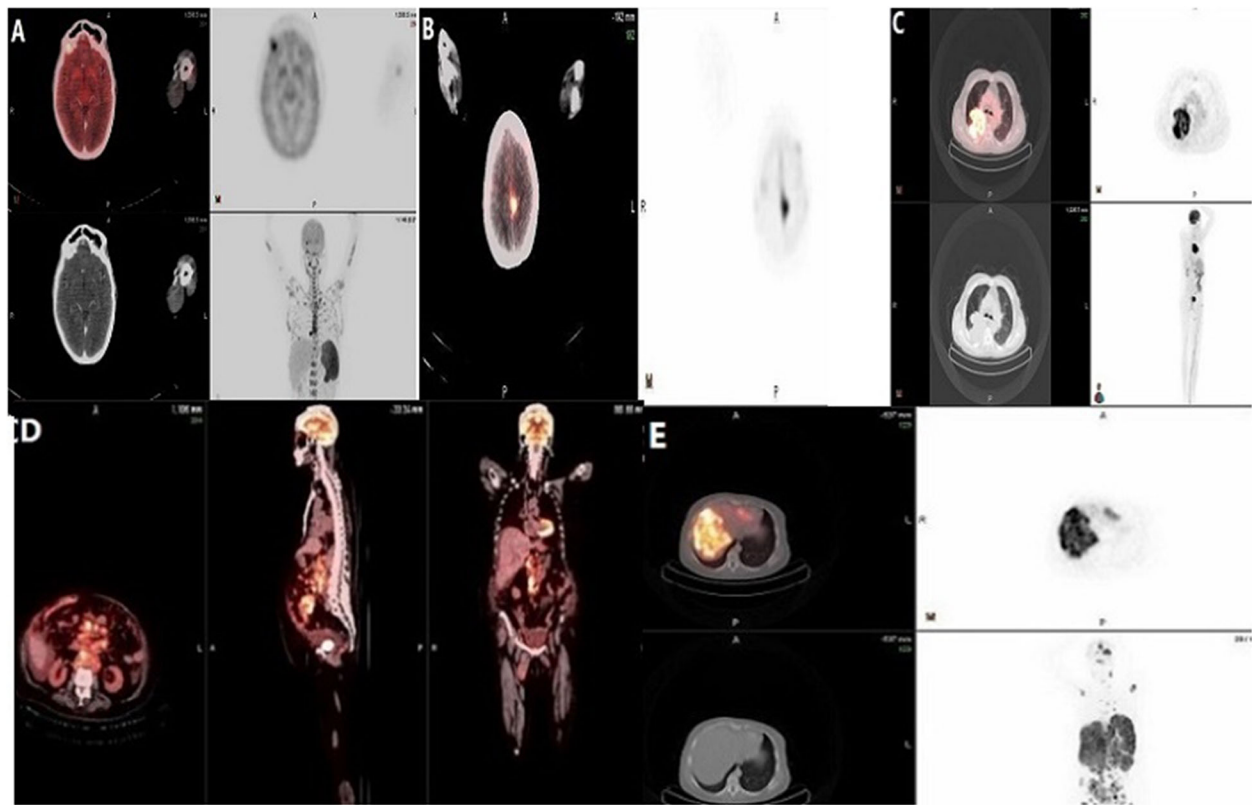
A 49-year-old male with brain metastasis in the right frontal lobe and left parasagittal region from an unknown primary. a, b Axial fused PET/CT and CT scan showed two active metastatic lesions seen in the right frontal lobe and another one in the left parasagittal region. c Multiplanar fused PET/CT and PET scan showed a large mass in the right lung with active uptake proved by bronchoscopic biopsy to be bronchogenic carcinoma. d Multiplanar fused PET/CT scan showed multiple metastatic para-aortic lymph nodes. e Multiplanar fused PET/CT and PET scan showed multiple metastatic active lesions in the liver
